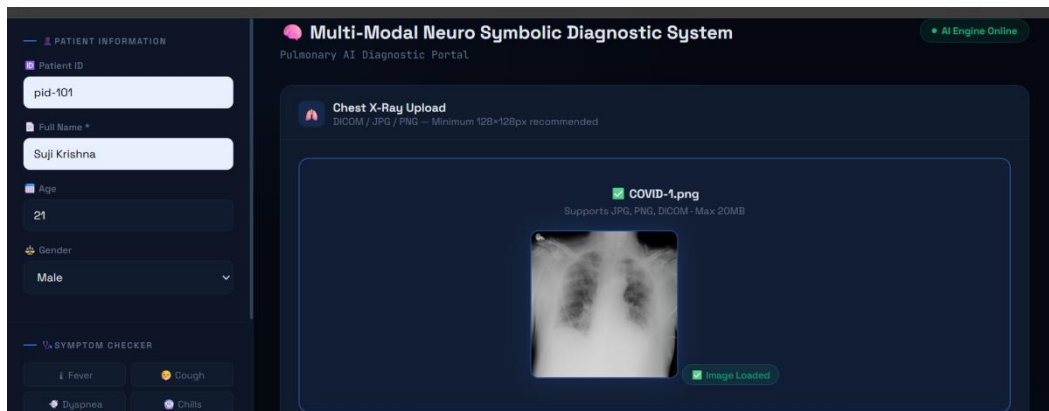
X-Ray Upload & Patient Input Form
